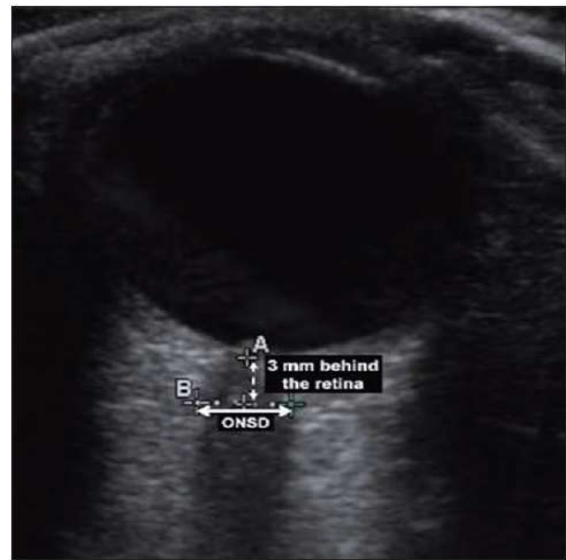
Ultrasound image showing optic nerve sheath diameter.
